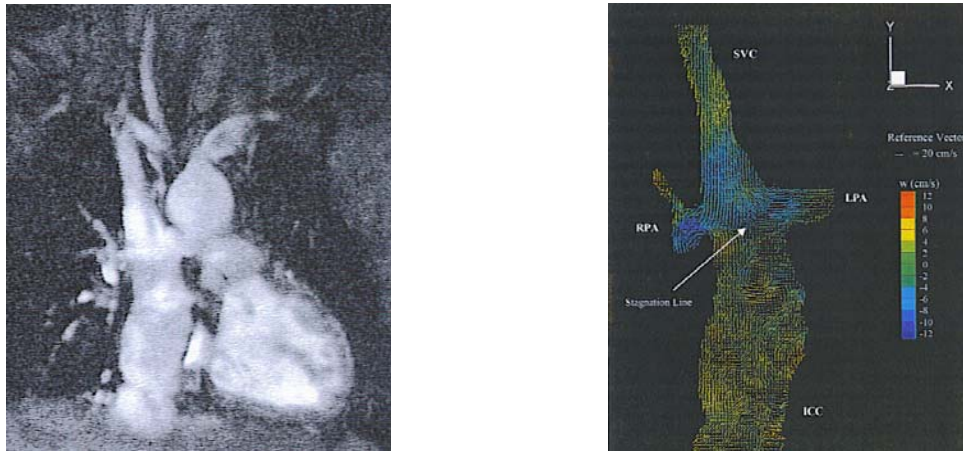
MRI phase contrast image and resulting velocity vector map of total cavopulmonary connection (Sharma, Ensley et al. 2001).
